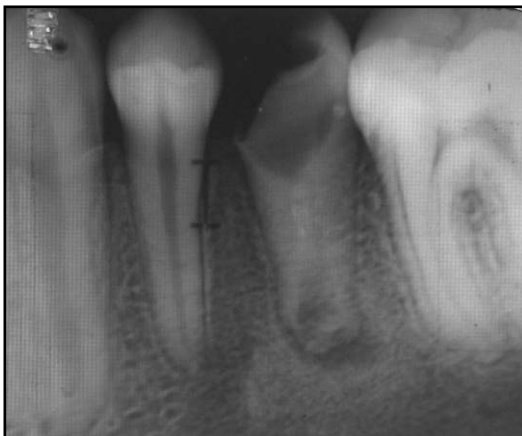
Radiographic image of 35, 6 months after MTA treatment, manifesting a closed apex
